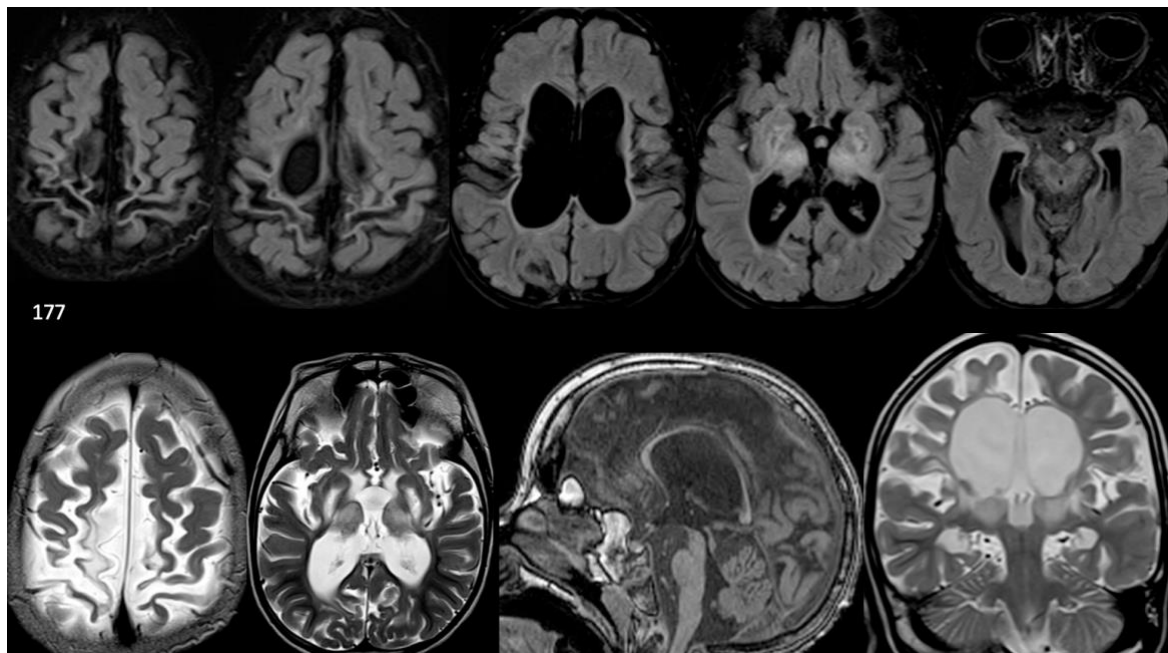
Collage of MRI images obtained for patient 177
